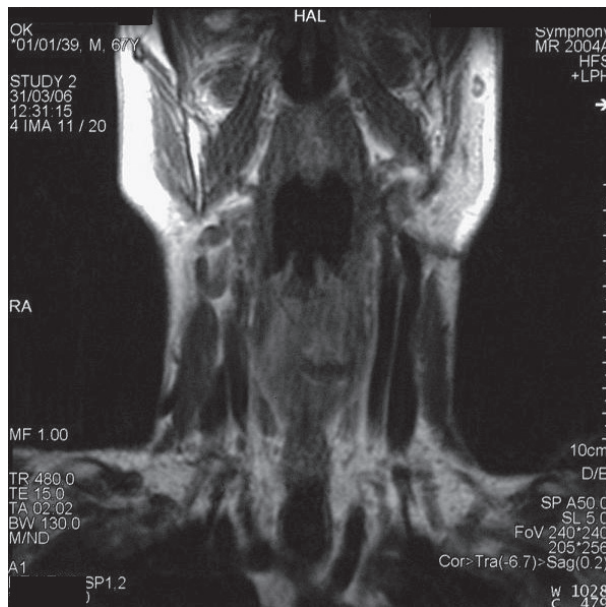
Five months postoperatively, this coronal, T1-weighted MRI with contrast shows that the airway is patent.
